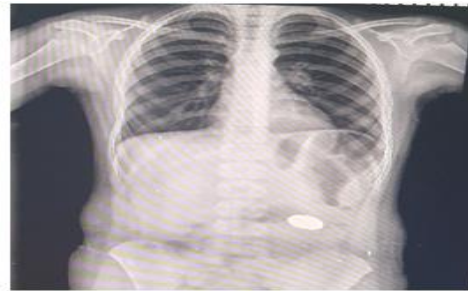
X-Ray of a 9 years old girl child showing foreign-body in small intestine.
